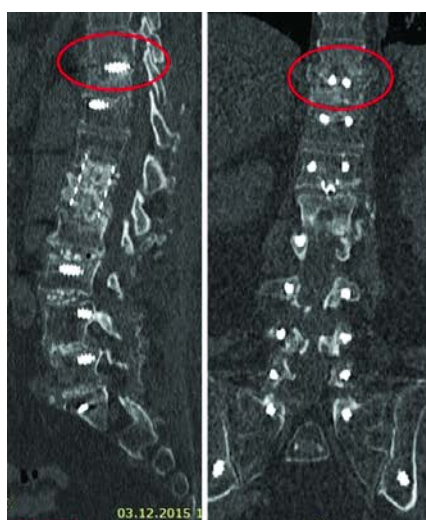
CT scans of the spine of patient S. with signs of destabilization of the screw in Th10 and fracture of the body Th9
